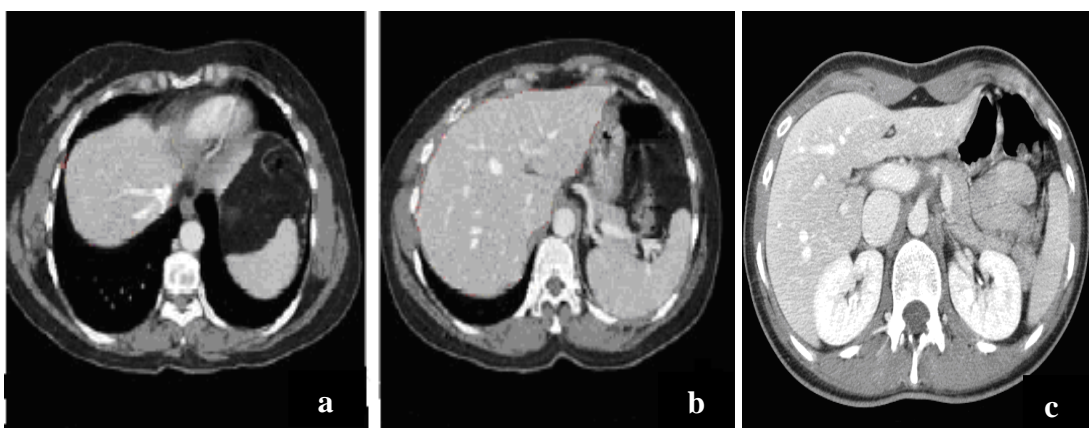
Different liver slices from a CT data set. Original images (a,b,c); Liver regions surrounded with red color (d,e,f); Segmented liver organ (g,h,i)
